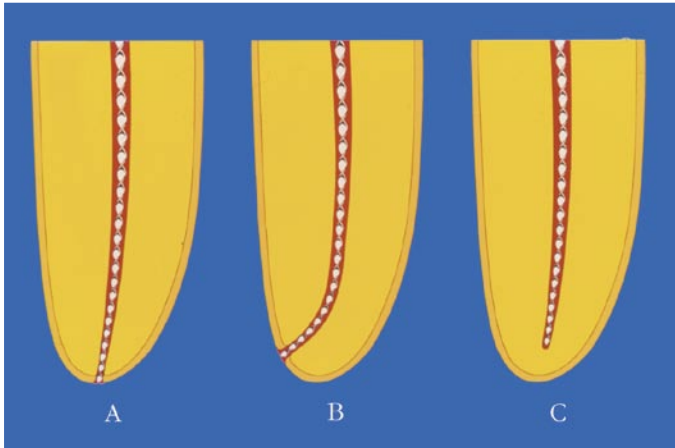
The radiographic appearance that the instruments have could be
